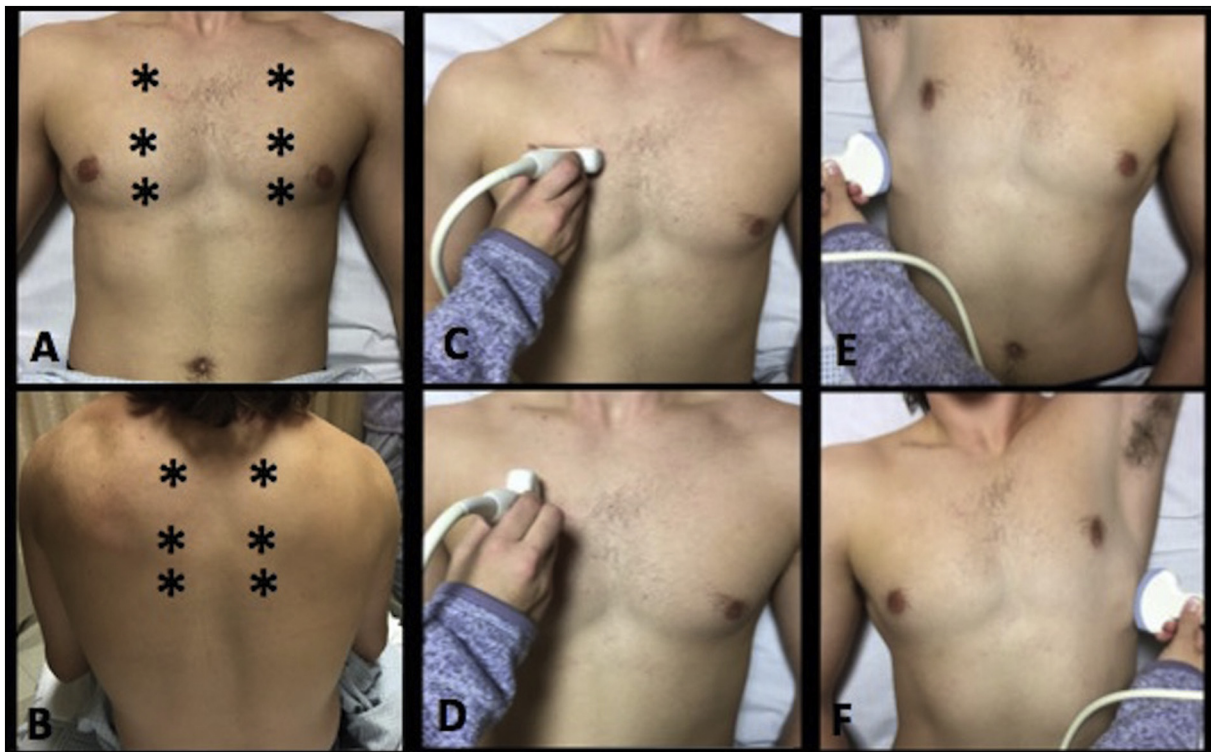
Bedside lung ultrasound protocol. Location of sonographic windows of anterior chest in the 1st, 3rd, and 5th intercostal spaces along the midclavicular line (A.); Location of sonographic windows on posterior chest in the 2nd, 4th and 6th intercostal spaces along the medial scapular line with patient's arms crossed in front (B.); Images were recorded in the transverse and sagittal plane for each intercostal space (C. and D.); Two additional coronal sonographic window were obtained to better visualize the right and left lung bases and to assess for pleural effusions (E. and F.).
